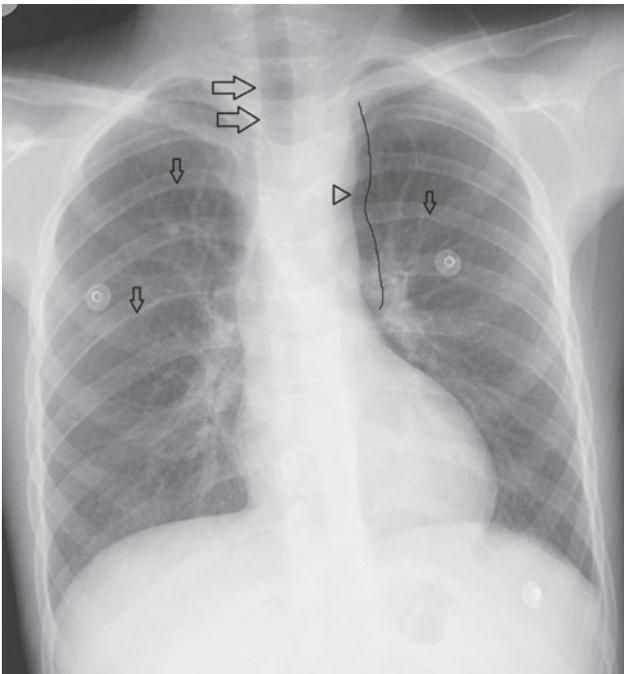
A PA chest X-ray shows stenotic segment of aorta (arrowhead) which forms 'figure of 3' sign (lines). Rib notching secondary to formation of intercostal collaterals is seen (short arrows). Tracheal deviation to the right side caused by the compression of haematoma is also shown (long arrows).
